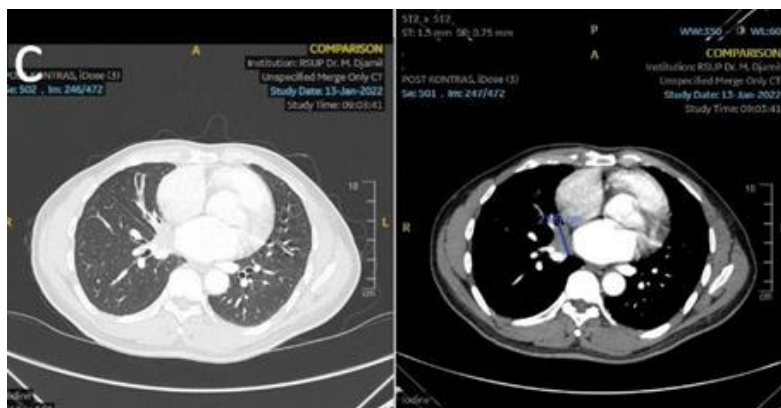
CT scan of the chest January 13th, 2022, second RECIST.
